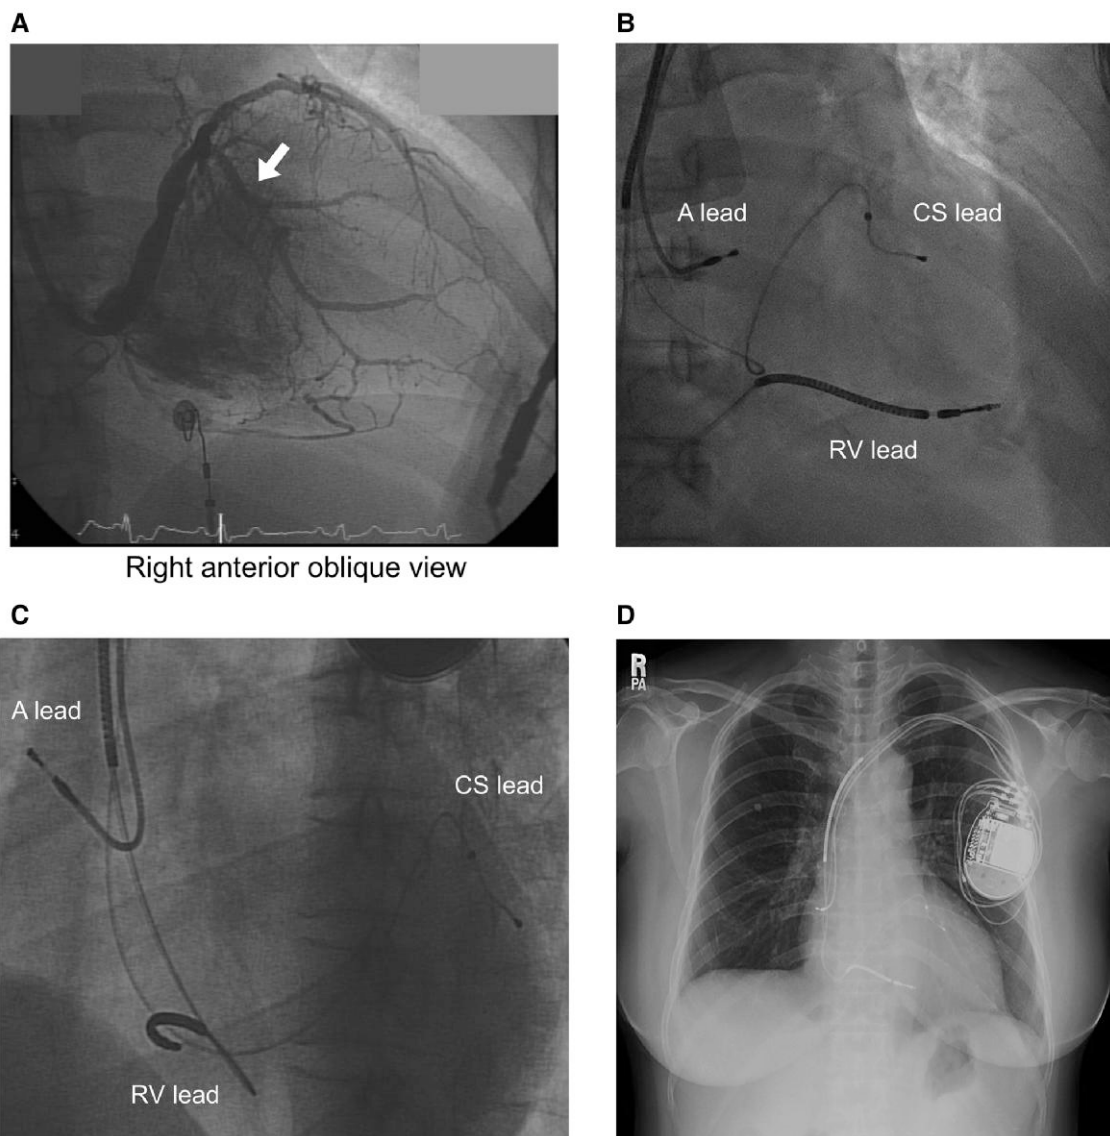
Fluoroscopy images during initial implantation of a cardiac resynchronization therapy-defibrillator 11 years before current presentation and chest x-ray image prior to the extraction procedure. (A) Venography showed a single appropriate branch vessel for cardiac resynchronization therapy implantation (white arrow). (B) Right anterior oblique view after implantation. (C) LAO view after implantation. (D) Chest x-ray image prior to the current extraction procedure. CRT-D, cardiac resynchronization therapy-defibrillator; CS, coronary sinus.
